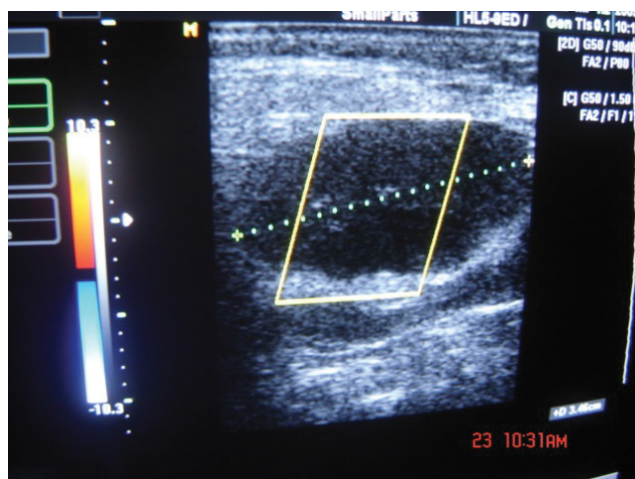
Ultrasonography of Sub mandibular lymph node
